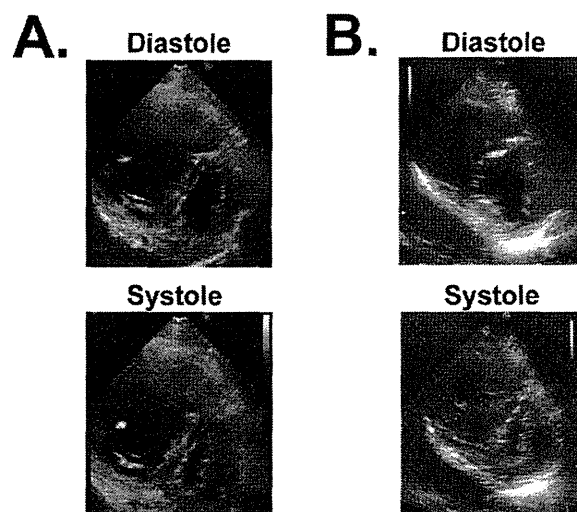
Transthoracic echocardiography on admission (A) and at 3 months after the initiation of treatment (B). Dilatation of the RV and left-side intraventricular septum were improved by the treatment.
